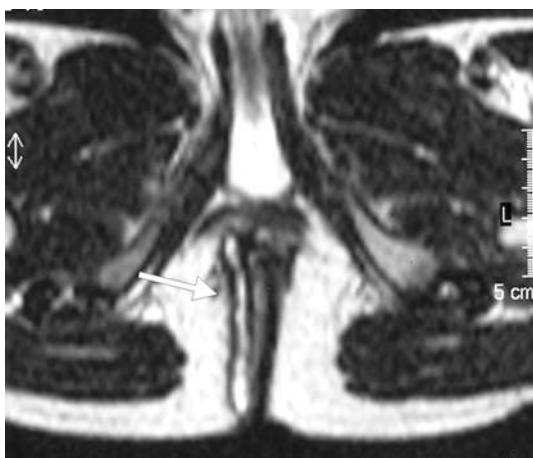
T2-weighted MR image is performed in axial plane and shows a fistula's track (*arrow*) in the right perianal fossa. Note a high signal of the fistula due to fluid filled cavities.
